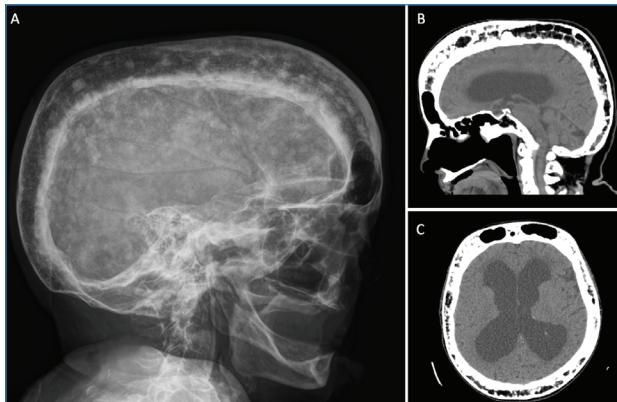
Radiography and computed tomography (CT) images
